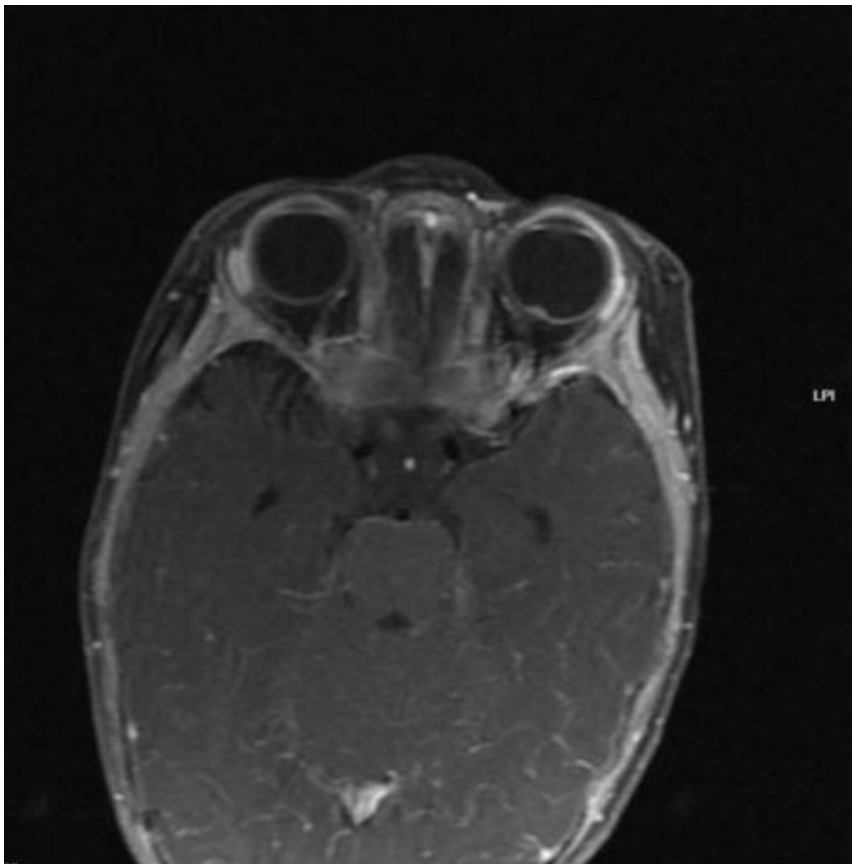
Axial MRI demonstrating the tumor in the optic nerve region. (21)
